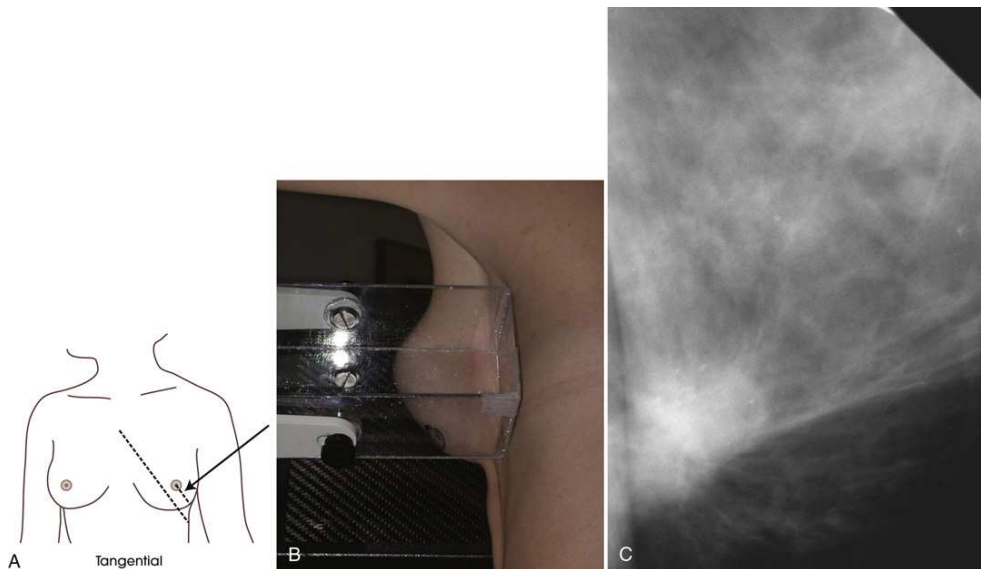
TAN projection of palpable mass in LOQ. (A) IR is angled parallel to nipple-to-mass line. (B) The mass, marked by *BB*, is positioned on edge of skin line. (C) Radiograph of mass imaged in tangent using the magnification technique. Spiculated borders indicate cancer.
